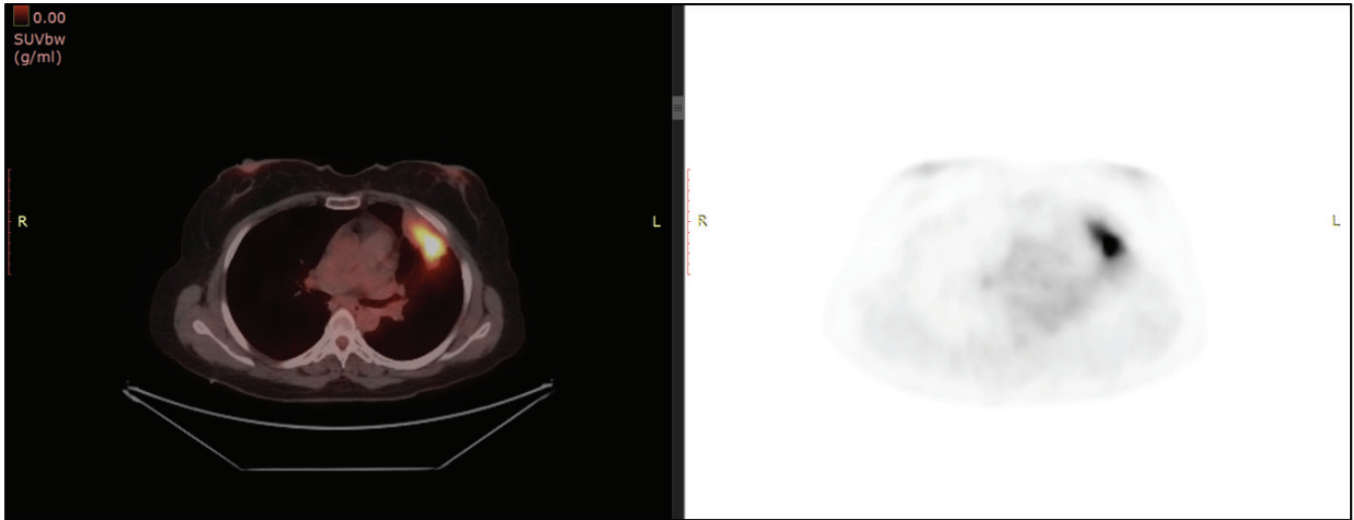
PET/CT scan showing hypermetabolic consolidation in the left upper lobe.
